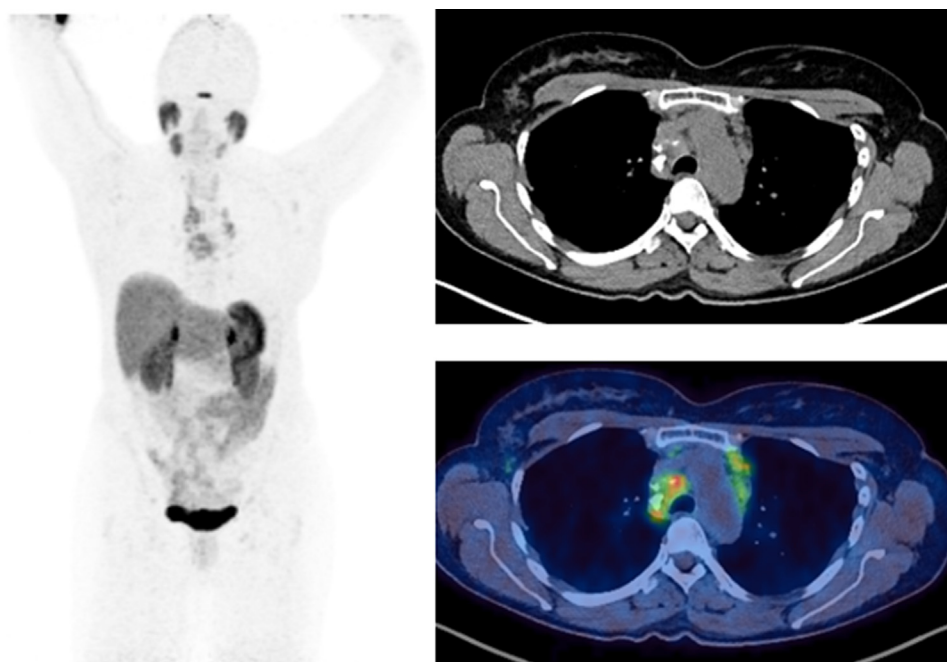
A 61-year-old woman with resected pancreatic NET had a surveillance ^{68}Ga -DOTATATE scan. ^{68}Ga -DOTATATE PET/CT demonstrates moderately intense uptake in calcified nodes: on review had been stable on serial CTs for 2 years. A biopsy of subcarinal node confirmed granulomatous disease, that is, sarcoidosis. Learning point: All areas of avid uptake are not necessarily NET. Review of previous imaging may be helpful in differentiating benign from malignant disease.
